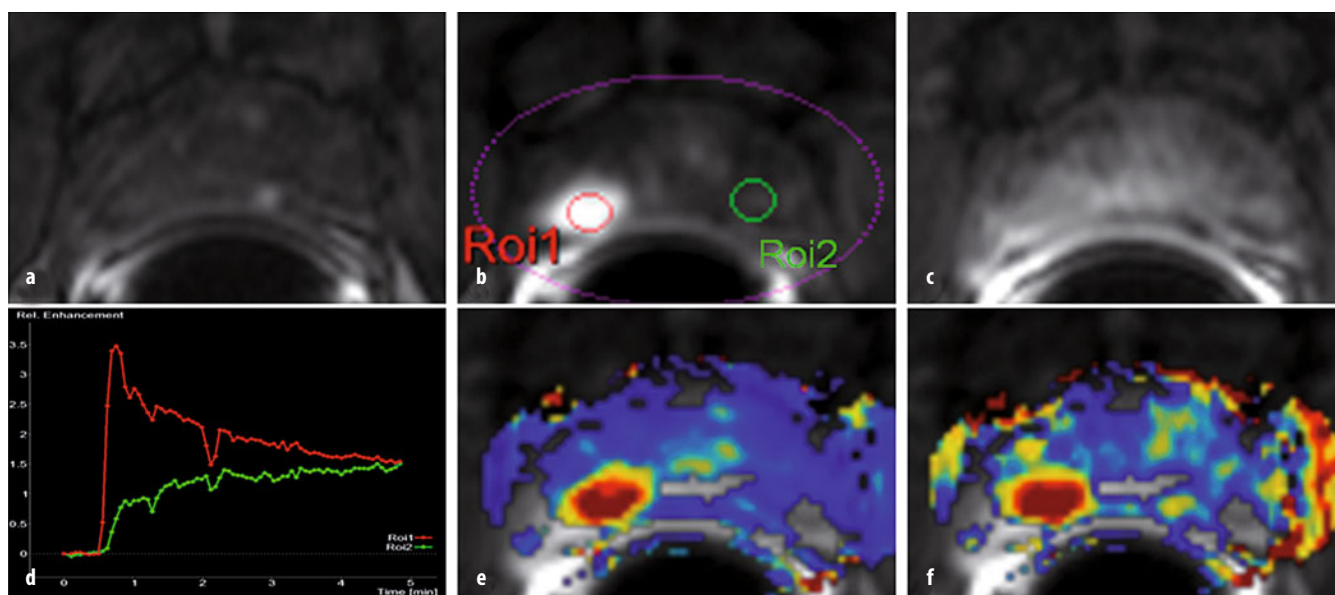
a-f. a Unenhanced axial T1-weighted gradient echo (GRE) sequence. b After contrast agent administration, an area with early enhancement is seen on the *right* in the peripheral zone (ROI1), with c significant washout in the late-phase image. d Enhancement can be graphically shown as signal intensity (SI)/time curve. A type III curve (*red*) with early enhancement is a typical finding in prostate cancer, whereas healthy prostate tissue is characterized by a steady, slow washin (type I, *green*). Parameter maps represent an alternative. e, f High-transport constants (K^{trans} and k_{ep} , respectively) confirm suspicion of prostate cancer. In this example, a minimally differentiated prostate adenocarcinoma with a Gleason score of $4 + 5 = 9$ was diagnosed after prostatectomy
